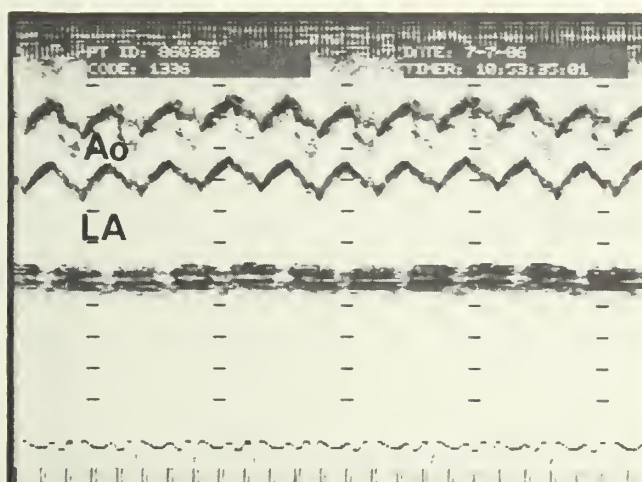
M mode echocardiogram (left) and 2-D echocardiogram (right) on the day after admission demonstrate the dilated left atrium and left ventricle. (LA=Left Atrium, AO=Aorta, LV=Left Ventricle.)
